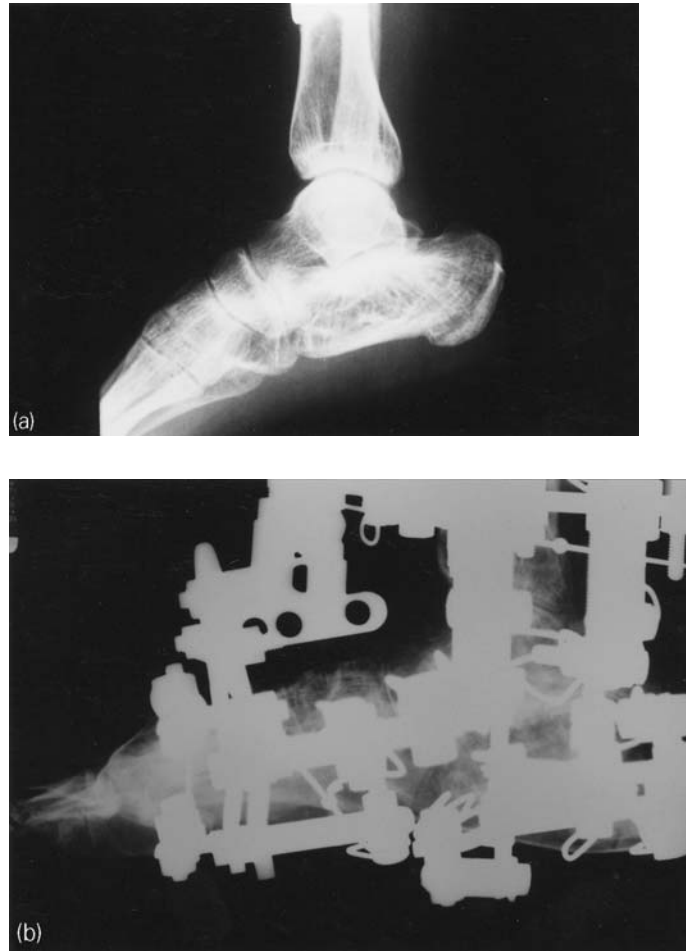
A 33-year-old woman with posttraumatic flat heel caused by a road accident. Treatment includes arthrodesis of the subtalar joint and a reversed, L-shaped calcaneal osteotomy (Figure 7.4a and b). (a) Radiograph before treatment. (b) Radiograph 20 days after the beginning of treatment. Note the visible regeneration within the calcaneal osteotomy. (c) The apparatus for simultaneous correction of the foot deformity and leg lengthening. (d) Lateral radiograph 1 month after removal of the apparatus. Note the arthrodesis of the subtalar joint and the trapezoidal bone regenerate in the calcaneus. (e) Functional result showing active plantarflexion. (f) Functional result showing active dorsiflexion.
